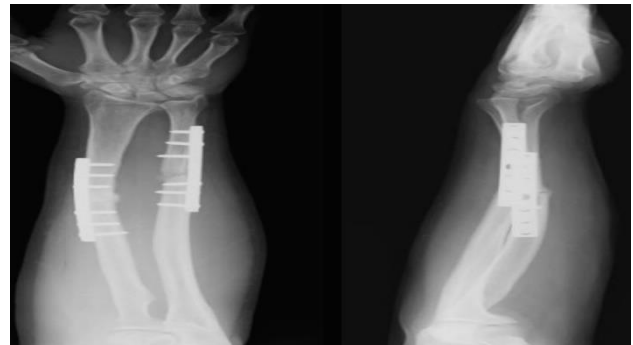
6 weeks post-operative x-ray.
